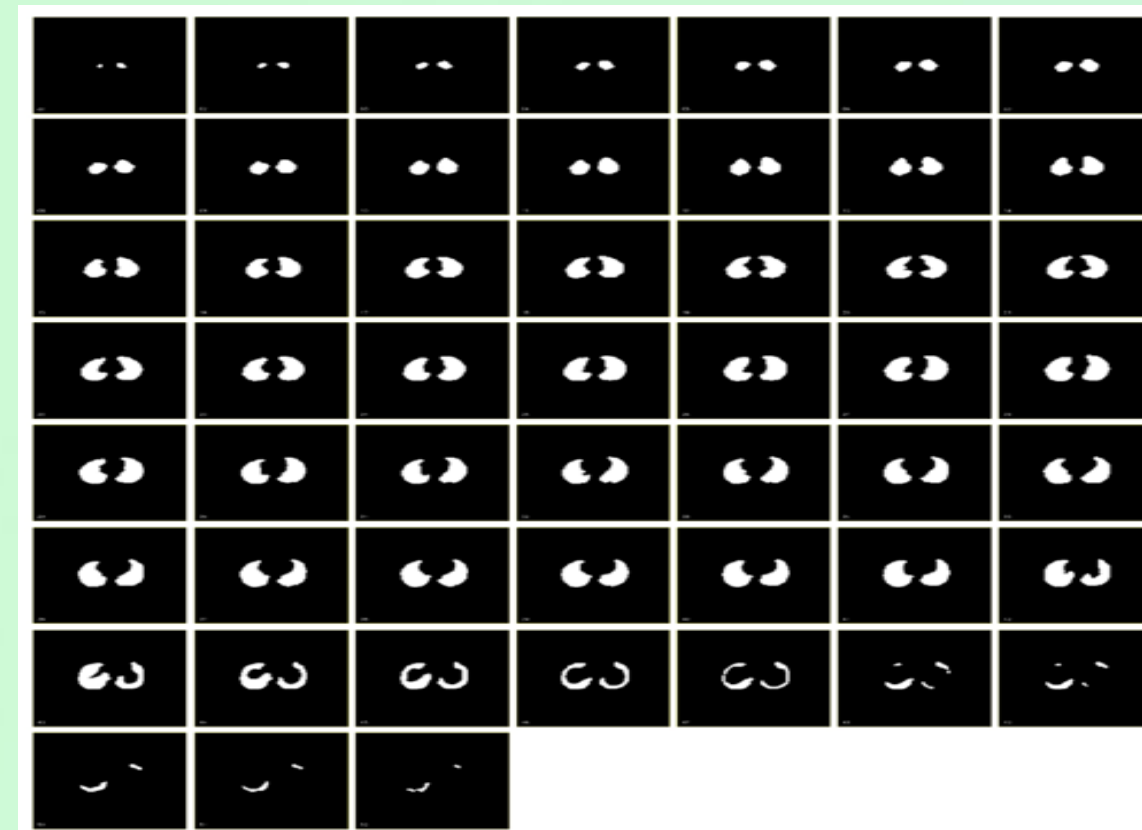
The transverse MR images, spanning the entire lung volume.
